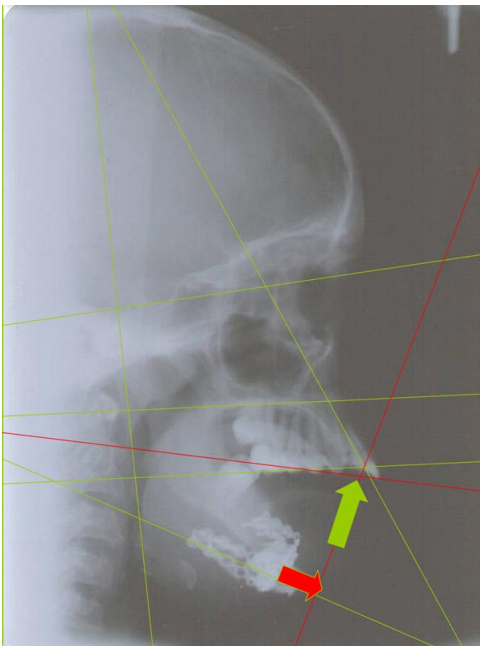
Lateral x-ray. The lines show the vertical and horizontal loss of the mandible. The arrows are indicating the ideal position for implantation.
